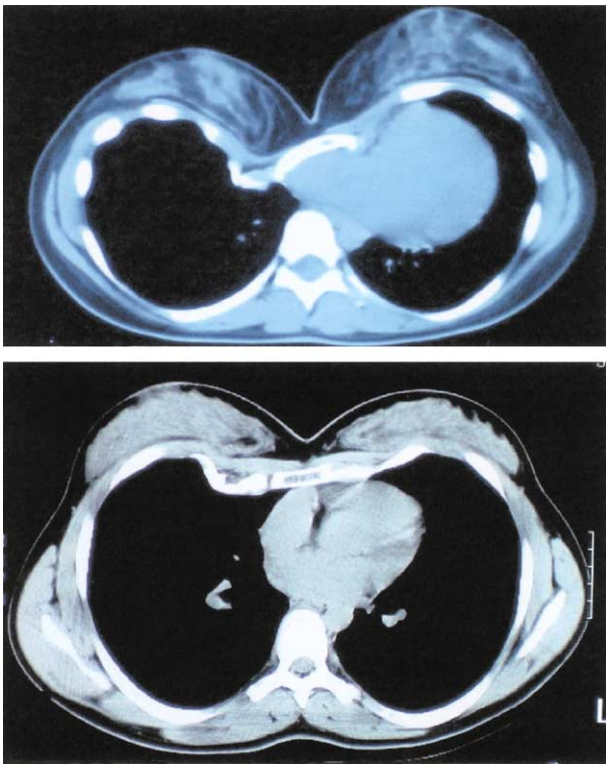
Computed tomography scans demonstrating abnormal ossification of the costochondral cartilages after Ravitch procedures in 2 patients.
